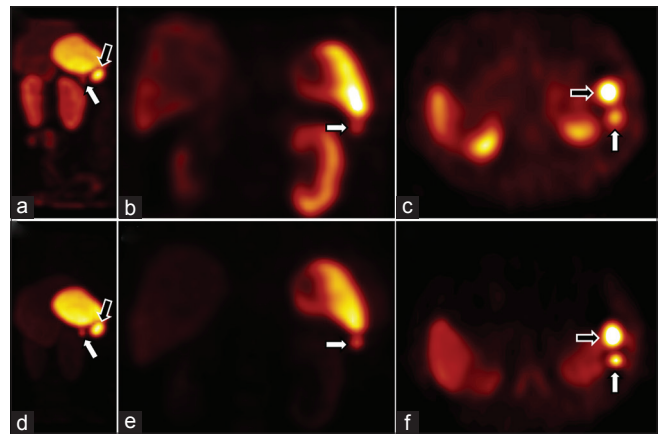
¹¹¹In-pentetreotide scintigraphy single-photon emission computed tomography showed two foci of increased uptakes adjacent to spleen (black arrow) and in the nephrosplenic space (white arrow) in (a) (raw image), (b) (coronal slice), and (c) (axial slice). Selective spleen scintigraphy using ^{99m}Tc-labeled heat denatured erythrocytes showed two foci of increased uptake which were matched with the lesions on somatostatin receptor scintigraphy and compatible with accessory spleen in (d) (raw image), (e) (coronal slice), and (f) (axial slice)
